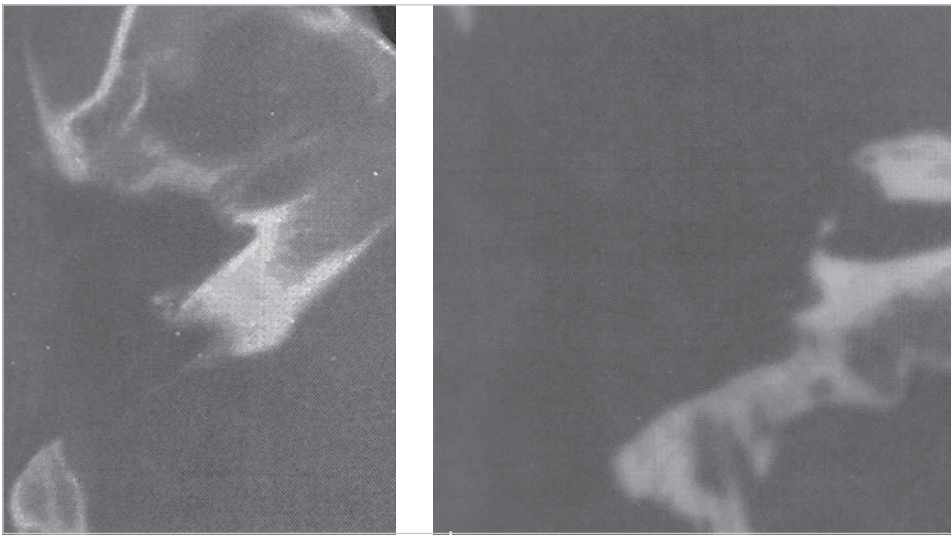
The postoperative CT scans demonstrate extensive bone removal from the posterior fossa (left; axial section) and the middle fossa (right; coronal section). The postoperative facial nerve function after 1 year reached acceptable H-B grade III with synkinesis.
